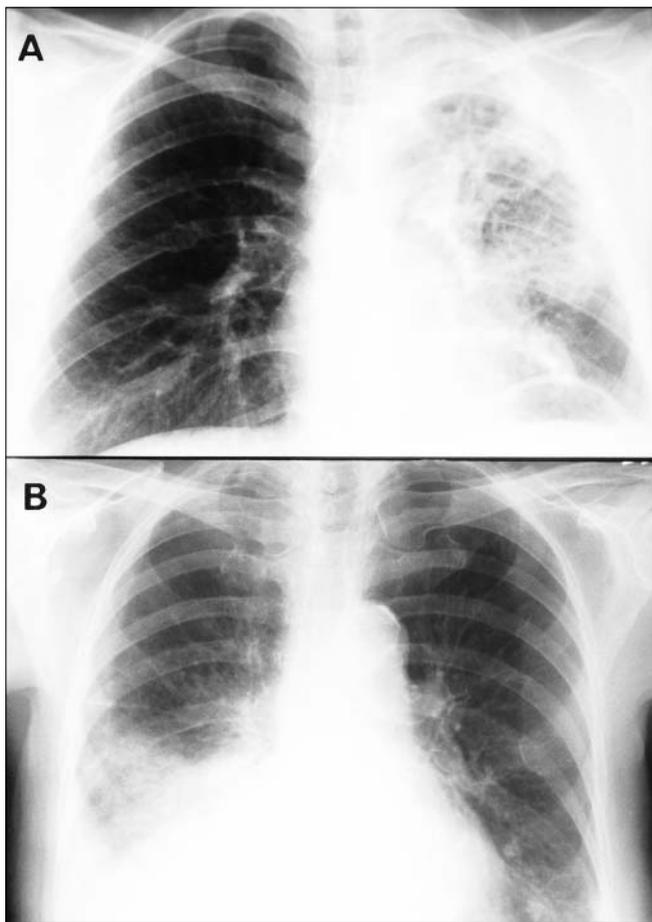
(A) Case 1. Posteroanterior chest radiograph obtained at the time of diagnosis demonstrates consolidation and moderate volume loss in the left upper lobe with at least 2 cavities at the apex, the largest measuring 4–5 cm in diameter. Reproduced, with permission, from Long and Maycher.¹ (B) Case 2. Posteroanterior chest radiograph obtained at the time of presentation to the family physician demonstrates bilateral pleural effusions, the right greater than the left, and collapse and consolidation of the right lower lobe.
